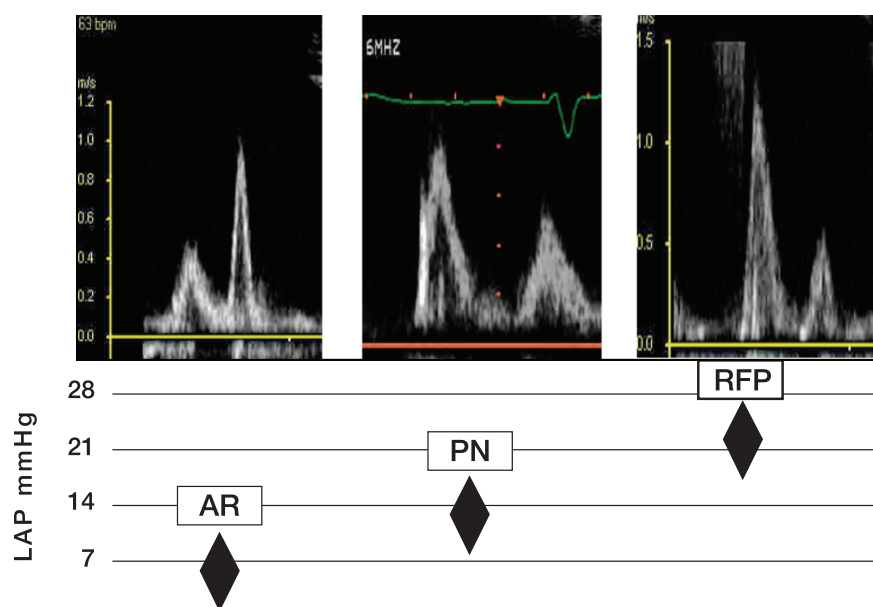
Doppler mitral inflow pattern in patients with systolic dysfunction (LVEF < 35%) and its relation to left atrial pressure. AR: abnormal relaxation, PN: pseudo-normal, RFP: restrictive filling pattern.
